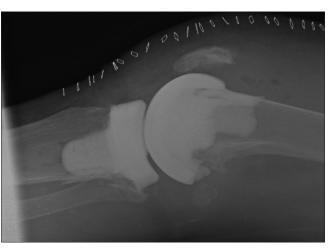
Lateral plain radiograph of a mobile cement spacer *in situ* having used the cement pedestal technique
